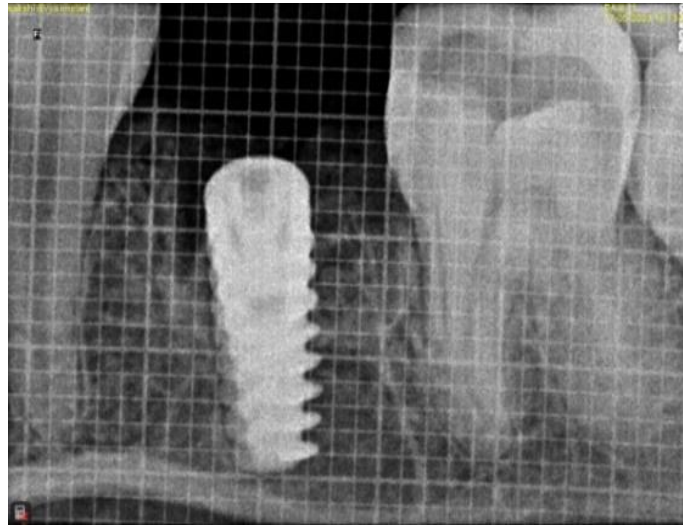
Radiographic finding at 1st week
